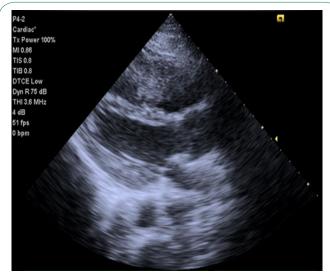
Echocardiogram revealing metastatic mass in Right Ventricular Cavity in parasternal long axis view.
